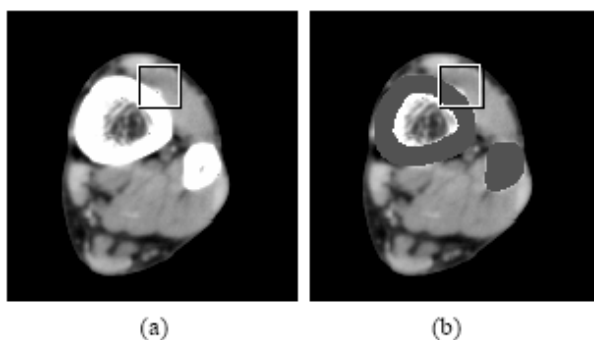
(a) A CTA image and (b) A segmented bone image
